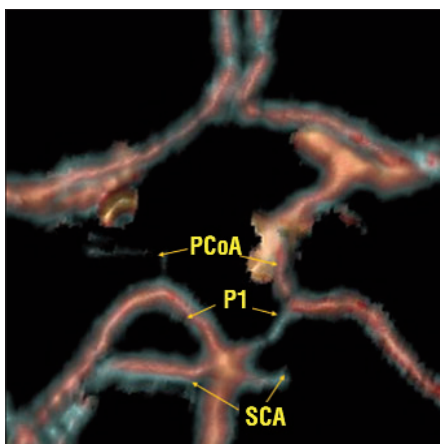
3D CT angiography reconstruction: left P1 segment hypoplasia. P1 - precommunicating segment of the PCA, PCoA - posterior communicating artery, SCA - superior cerebellar artery
